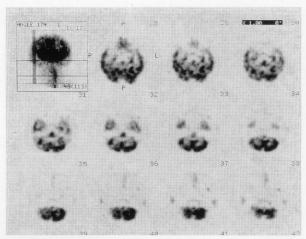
SPECT after the surgery demonstrates the recovered perfusion in the pons and improved perfusion in the right cerebellar hemisphere.
